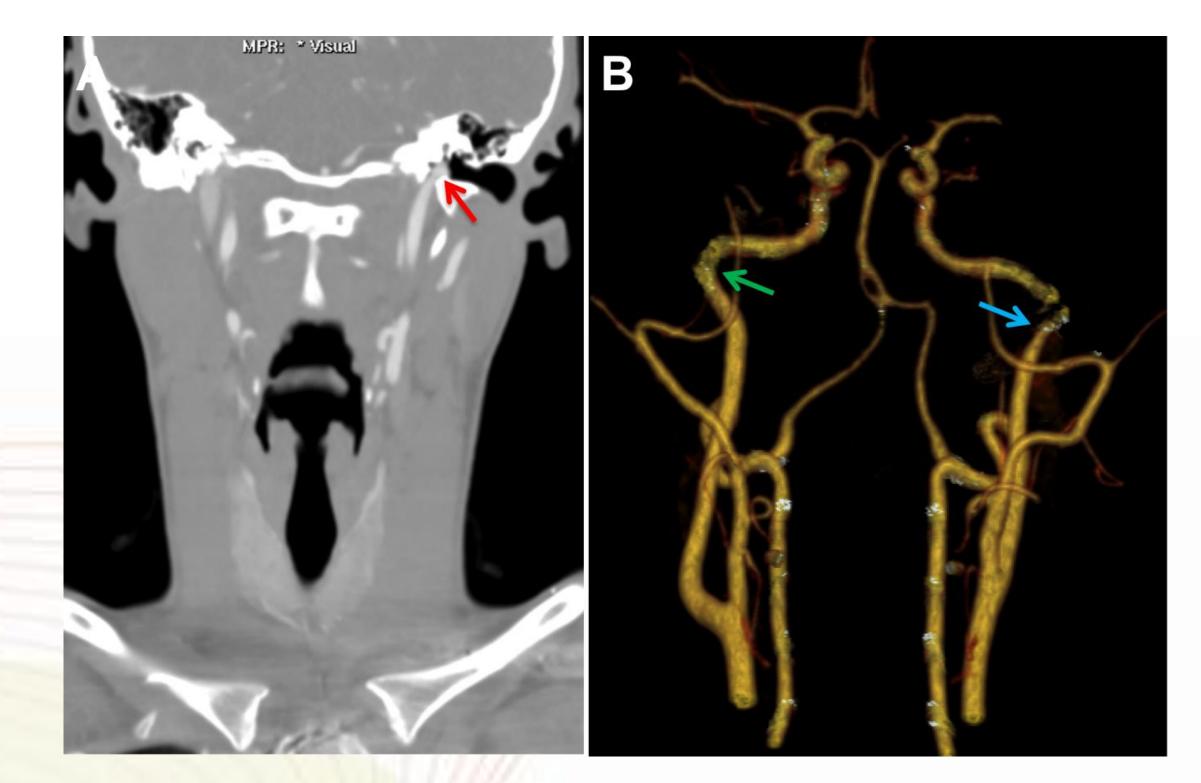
Typical CTA case showing left aberrant ICA. Coronal CTA image (a) through the enlarged inferior tympanic canaliculus (red arrow) reveals the stenosed artery within this structure. CTA reprojection image (b) reveals the left ICA with significant irregularity and stenosis visible (blue arrow). This alone should allow the radiologist to make the diagnosis of left aberrant ICA. The right ICA is normal (green arrow). Frontal CTA reprojection demonstrates the angulated aberrant ICA (blue arrow) compared to the smooth opposite right ICA (green arrow).
